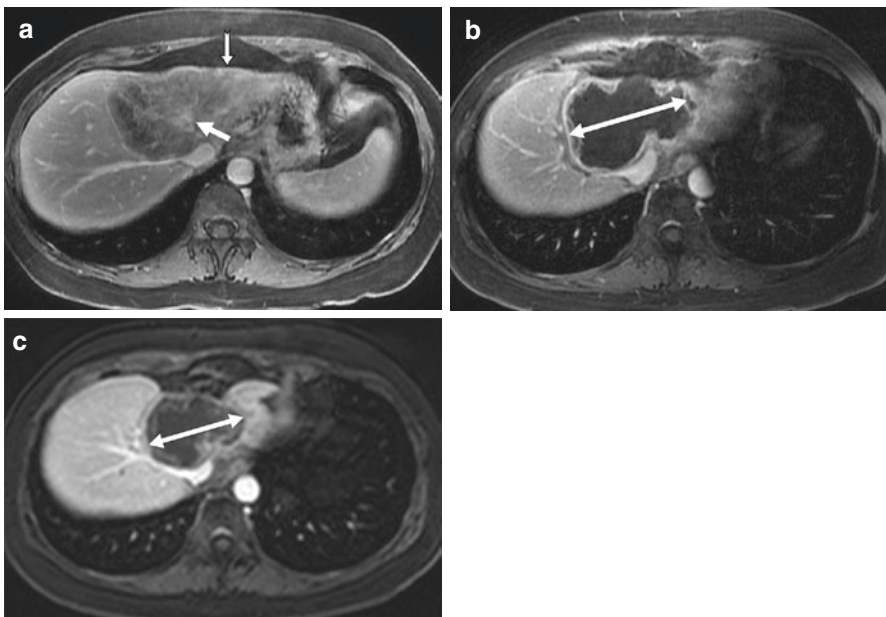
Baseline T1-weighted post-contrast image (a) shows a mass-forming intrahepatic cholangiocarcinoma with central enhancement (arrow) and capsular retraction (notched arrow) before treatment. T1-weighted post-contrast images show favorable response to trans-arterial chemoembolization therapy with decrease in tumor enhancement and size (double arrows), 4 months (b) and 10 months (c) following therapy, respectively
